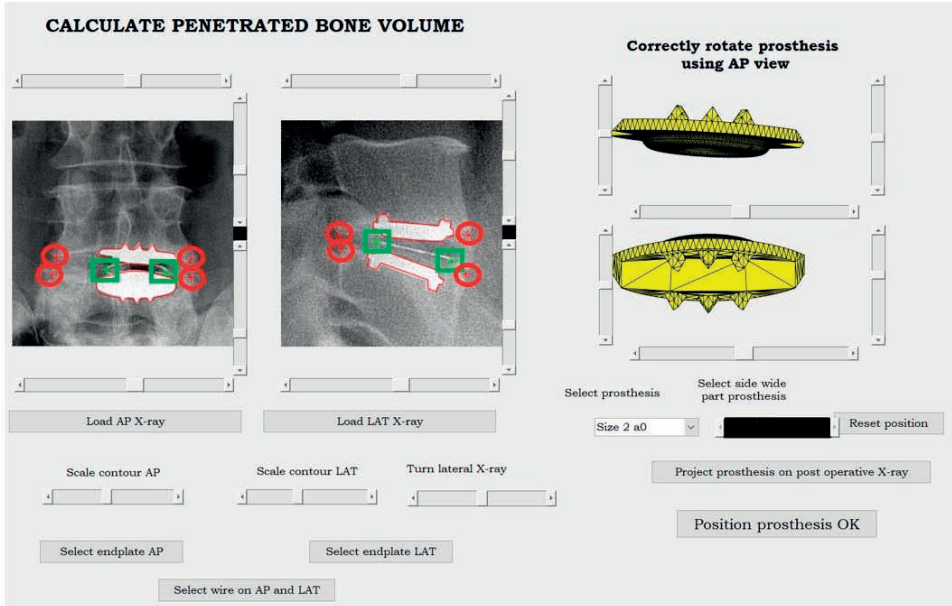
The 3-dimensional graphical representation of the TDR implant in relation to the bony endplates. This representation can be rotated manually until its contour best replicates the outline of the implant on both AP and lateral radiographs. Next, the most lateral left and right points of the bony endplate on the AP radiograph and the most anterior and posterior points of the bony endplate on the lateral radiograph were identified (red circles). Similar points had to be indicated on the metal ring of the circular polyethylene insert (green squares). The latter were used to correct for the difference in magnification factor between the AP and lateral radiograph of the same patient.
